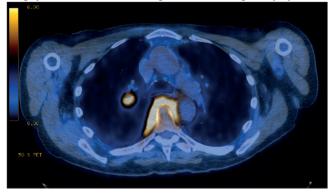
CT-PET showing uptake in the prevertebral and bilateral paravertebral region, (SUV max 11.92), PET avid right hilar nodes (SUX max 6.7) with encasement of the descending aorta, associated with increased uptake.
